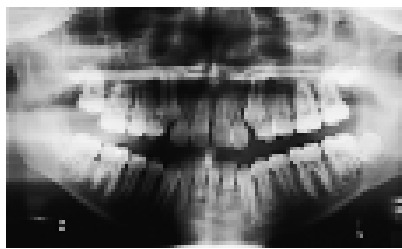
Orthopantomogram of case 2.
